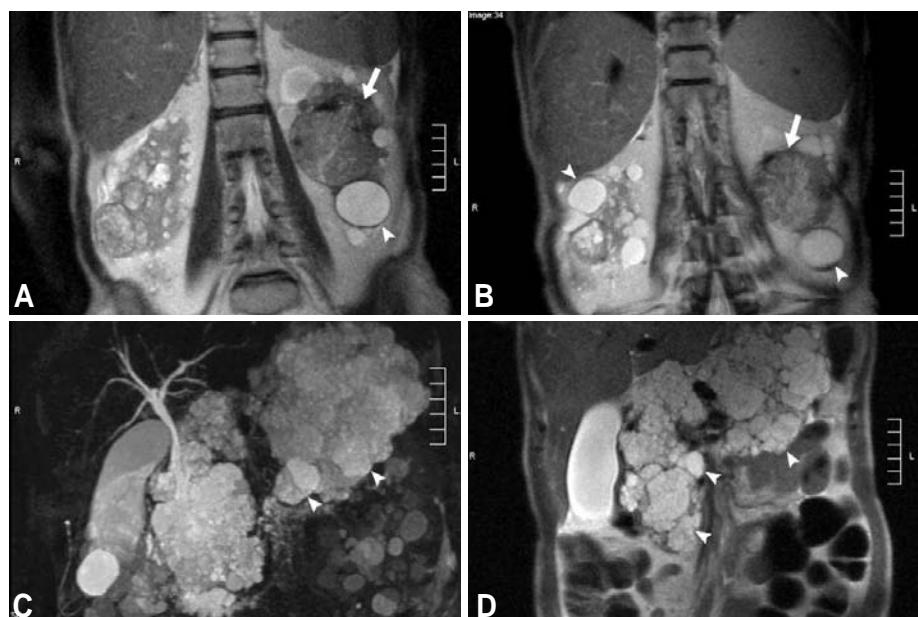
Abdominal MRI in a patient with VHL disease. A,B Numerous renal cystic structures (arrowheads) and a solid renal mass (arrows). Coronal T2-weighted MRI images. C,D Numerous pancreatic cysts (arrowheads). Coronal T2-weighted MRI images.
